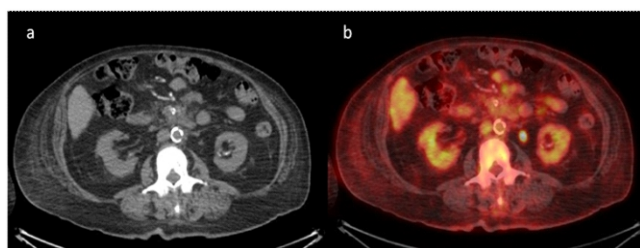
A 68 years old woman with ESRD on hemodialysis who underwent ^{18}F -FDG PET/CT imaging. Computed tomography image and fusion PET/CT image (a, b) show high attenuation extensive circumferential macroscopic atherosclerotic calcification in the abdominal aortic wall. Standardized uptake maximum value and SUVmean were 3.8 and 3.6 for abdominal aorta, respectively, measured from a non-calcified region.
